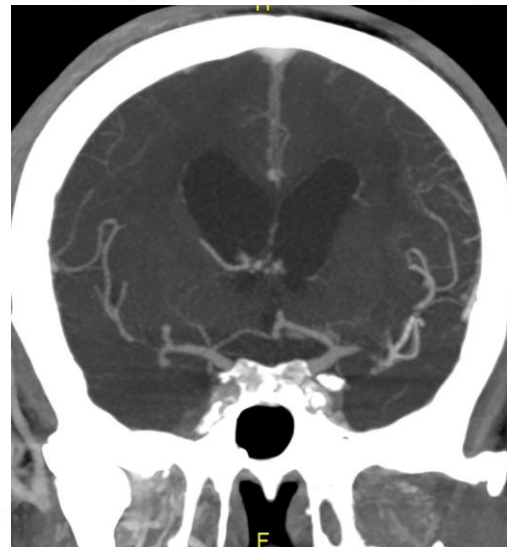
Coronal CT MIP single phase showing poor collateral score (TAN grade 2)
